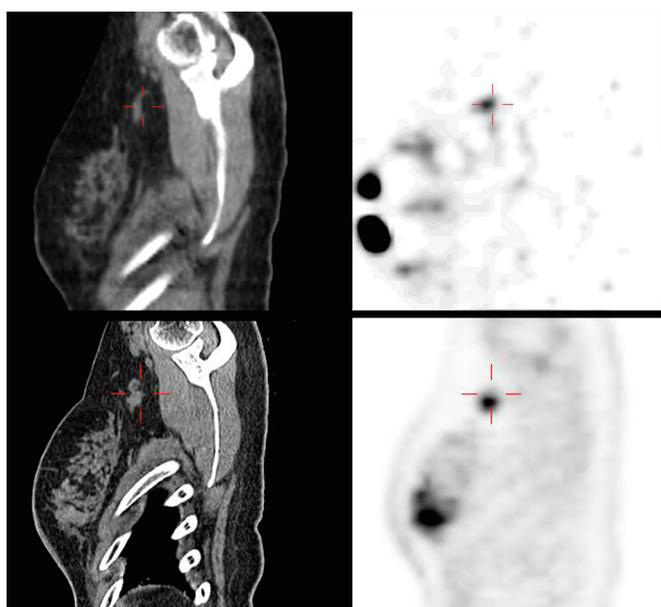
^{99m}Tc-Nanotop SPECT/CT (top) and FDG PET/CT (bottom) images of a patient with concordant level-1 right axillary lymph b-sagittal.
